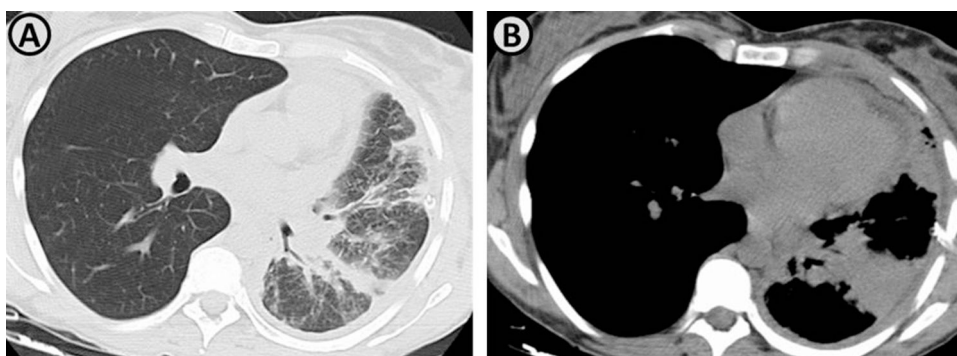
(A and B) Axial thoracic computed tomography images demonstrate the presence of a pulmonary mass in the left lower lobe, with perihilar localization, conditioning partial atelectasis of this lobe. There is also seen interlobular septal thickening, suggestive of lymphangitic carcinomatosis.
